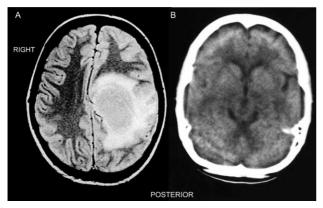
Magnetic resonance imaging – brain tumour in the left parasagittal temporo-parietal region (a); Computed tomography – postoperative encephalomalacia of the left parietal area (b).
